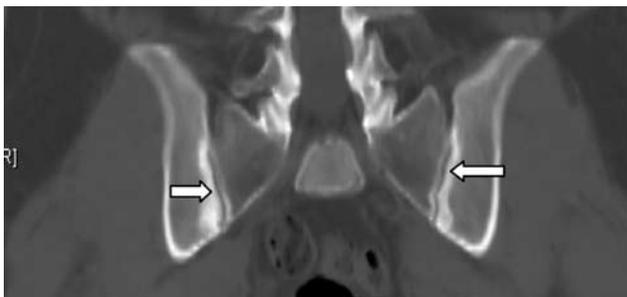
Axial CT scan shows erosions and iliac side subchondral sclerosis of both sacroiliac joints (arrows).
